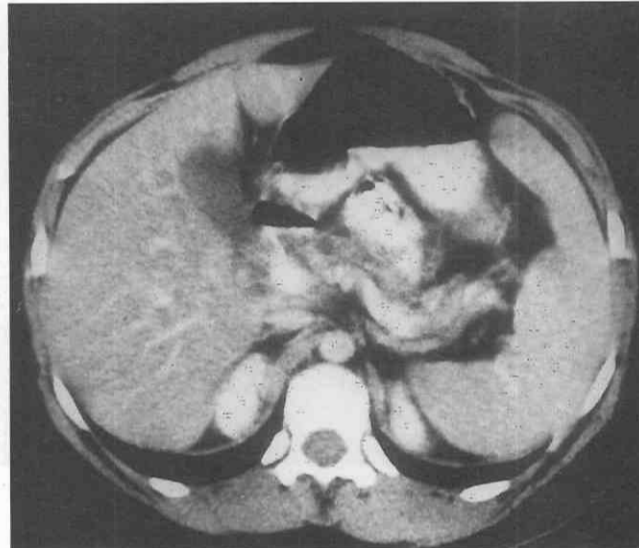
Chronic pancreatitis. CT scan through the pancreas in a patient with chronic pancreatitis demonstrates a small, atrophic pancreas.
